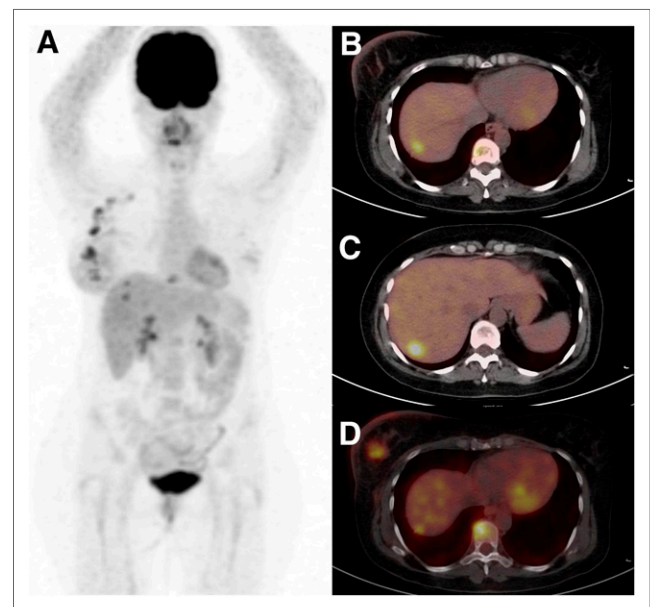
^{18}F -FDG PET/CT at initial staging in 46-y-old patient with invasive ductal carcinoma of right breast, classified as clinical stage IIIA disease. (A) Maximum-intensity projection. (B–D) Axial PET/CT fusion images showing liver (B and C) and bone (D) metastases.
